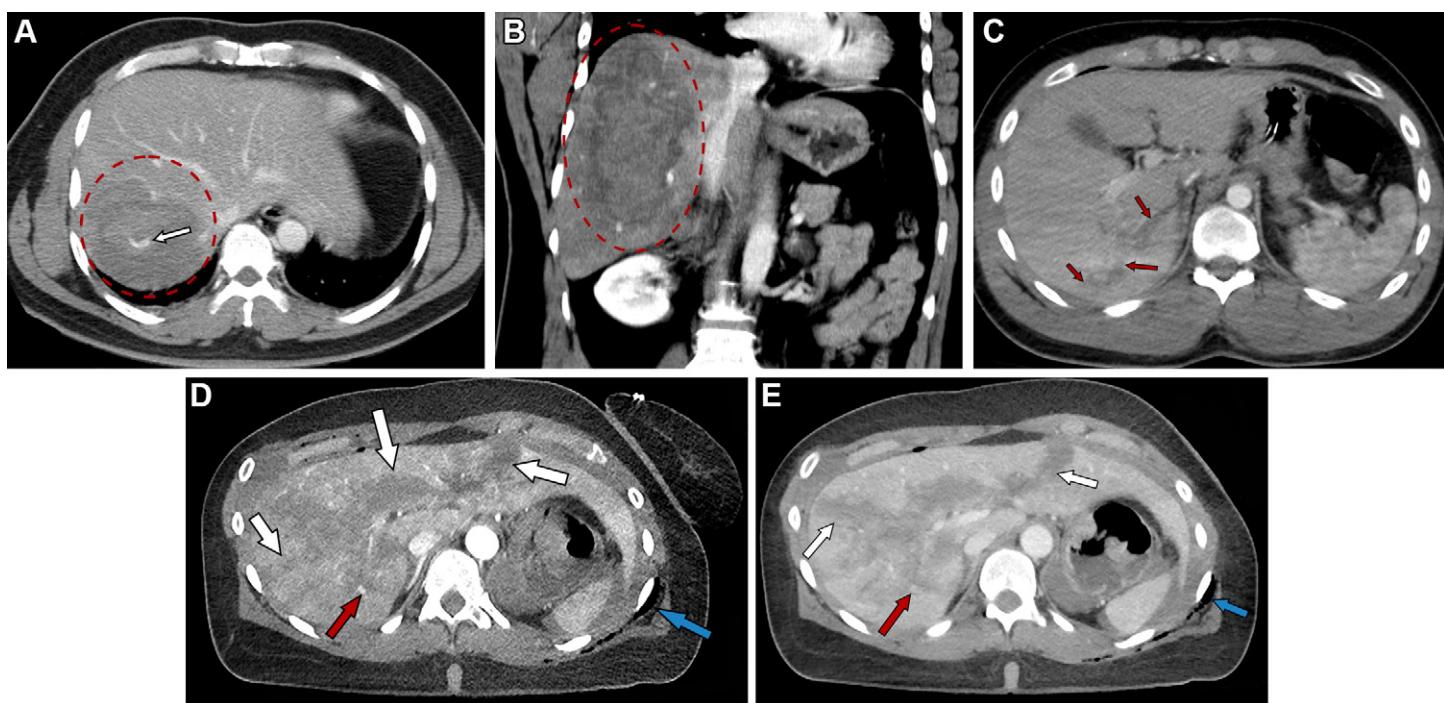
Grade III liver injuries according to the revised 2018 AAST-OIS. (A, B) Axial (A) and coronal (B) contrast-enhanced CT images in a 45-year-old man after a motor vehicle collision show a large intraparenchymal hematoma in the posterior right lobe (red circle in A, red oval in B) measuring $5.5 \times 3.3 \times 10.1$ cm with active extravasation (arrow in A) and no capsular disruption. Inclusion of vascular injuries with active bleeding contained within the liver parenchyma was one of the changes brought on by the AAST-OIS 2018 revision. An axial cine clip of this patient is shown in Movie 8. According to the AAST-OIS 2018 revision, the term *expanding* was removed for both subcapsular and parenchymal hematomas. (C) Axial contrast-enhanced CT image in a 37-year-old woman after a motor vehicle collision shows a hepatic laceration (arrows) measuring approximately 7 cm in length and over 3 cm in depth. (D, E) Axial arterial (D) and portal venous (E) phase contrast-enhanced CT images in a 45-year-old woman after a motor vehicle collision show multiple large liver lacerations (white arrows) and a contrast material–attenuation focus (red arrow), which partly washes out in the portal venous phase and does not increase in size, suggestive of a contained vascular injury. However, the patient underwent angiography, which failed to reveal the injury. The patient was managed conservatively, but her hematocrit level continued to drop. Second-look angiography 2 days after presentation revealed a large contained vascular injury, which was successfully embolized. Also note the air adjacent to the rib cage (blue arrow) and the hemoperitoneum.
